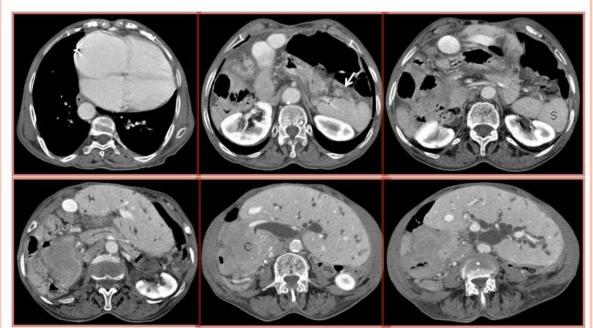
Situs ambiguous with polysplenia in a 85-year-old woman. Contrast-enhanced TC scan of the lower chest reveals levocardia. CT scan of the upper abdomen reveals a predominantly left-sided liver, with bile duct dilatation secondary to a carcinoma (C) of the pancreatic head, which is right-sided. The stomach and the spleen (S) are in the left upper quadrant, with a few small acessory spleens (arrow) near the splenic hilum. The aorta is located at the left of the midline and the IVC at the right.
